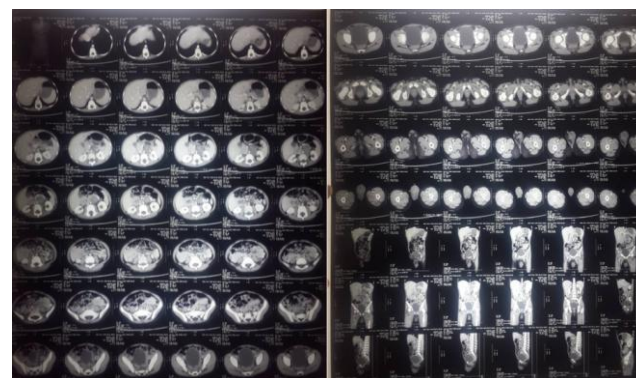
Computed Tomography of Lower Abdomen Post Neo Adjuvant
